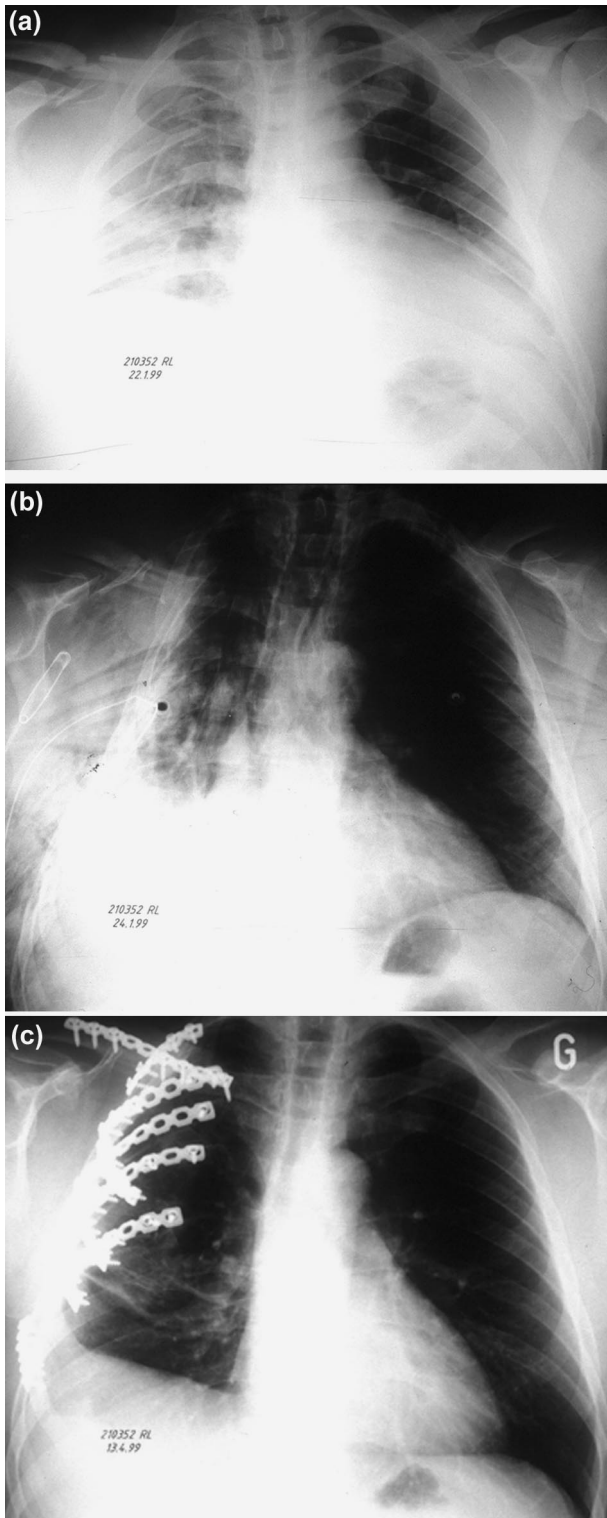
Chest X-rays of a patient with flail chest: (a) at admission, conservative therapy with peridural analgesia and physiotherapy; (b) 2 days after admission, massive shrinkage of the chest wall, respiratory insufficiency requiring intubation; (c) 3 months following operative stabilisation.
